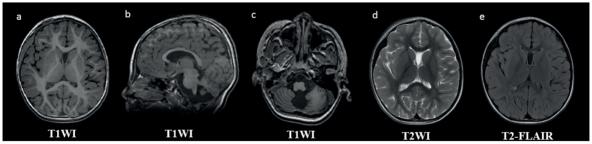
Magnetic resonance imaging (MRI) of the brain: (a) Axial T1-weighted MRI of the brain shows normal findings; (b) Sagittal non-contrast T1-weighted MRI of the brain indicates the cerebellar volume; (c) Axial T1-weighted MRI demonstrates a relatively well-formed, nonrotated cerebellar vermis. The medial cerebellar hemisphere was symmetrically pressed, forming a typical keyhole-like fissure (Blake's pouch cyst); (d) Axial T2-weighted MRI of the brain demonstrates septum pellucidum; (e) Axial FLAIR images demonstrate normal findings.
